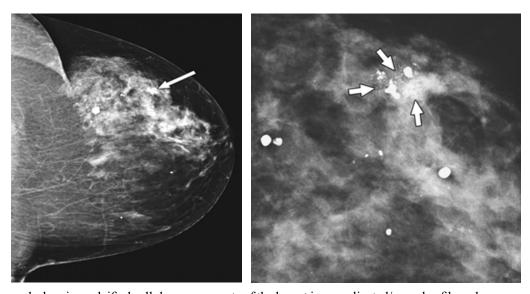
A radiograph showing calcified cellular components of the breast in complicated/complex fibroadenoma cases of ages 40-59.
